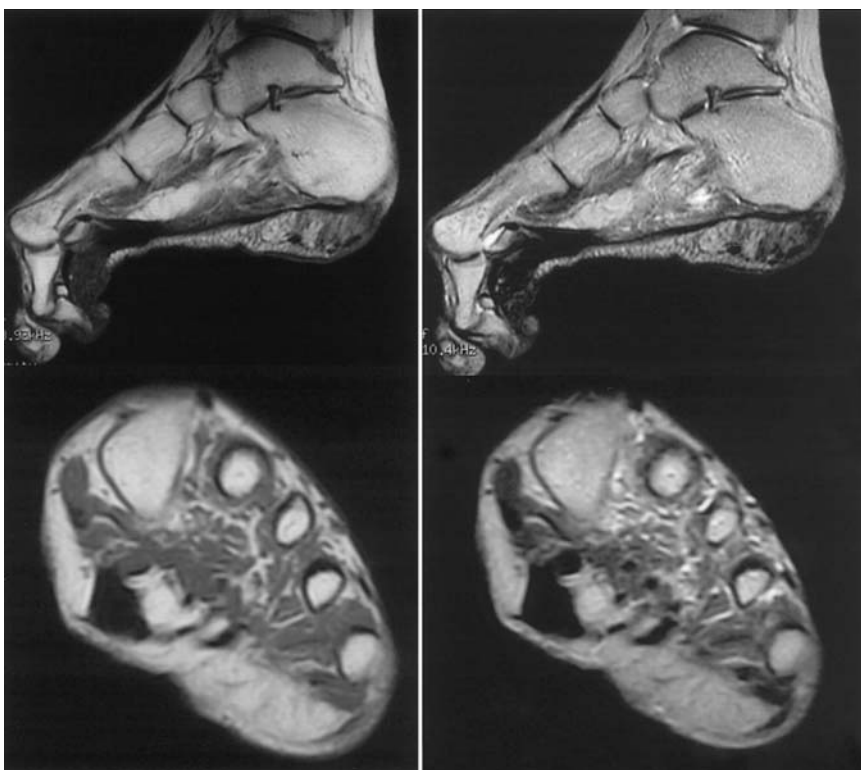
T1-weighted and T2-weighted magnetic resonance imaging (MRI) scans of the left foot before surgery. A thick, cord-like aponeurosis is evident on the sole of the left foot
